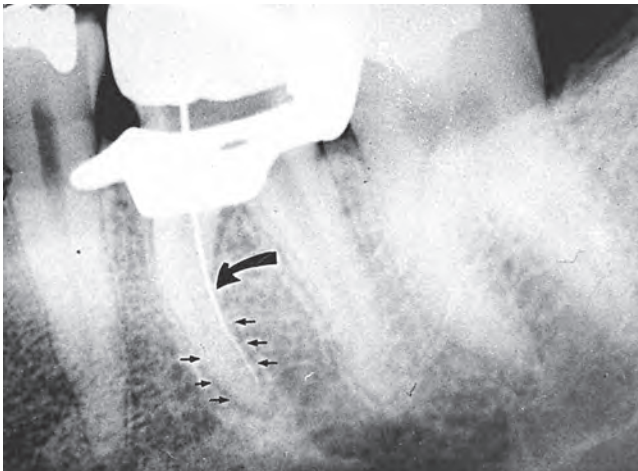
Radiograph used in search for a second, missed canal. By following the lamina dura of the root (*small arrows*), the eccentric position of the file (*large arrow*) suggests the possible presence of a missed canal. However, the file has actually passed through a perforation and is traversing the periodontal ligament. Look for bleeding in the pulp chamber.
